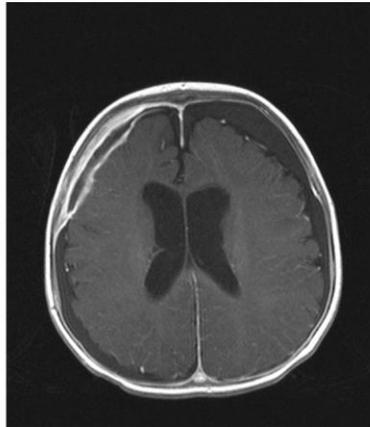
MRI images showing subdural empyema (right) and subdural effusion (left).
